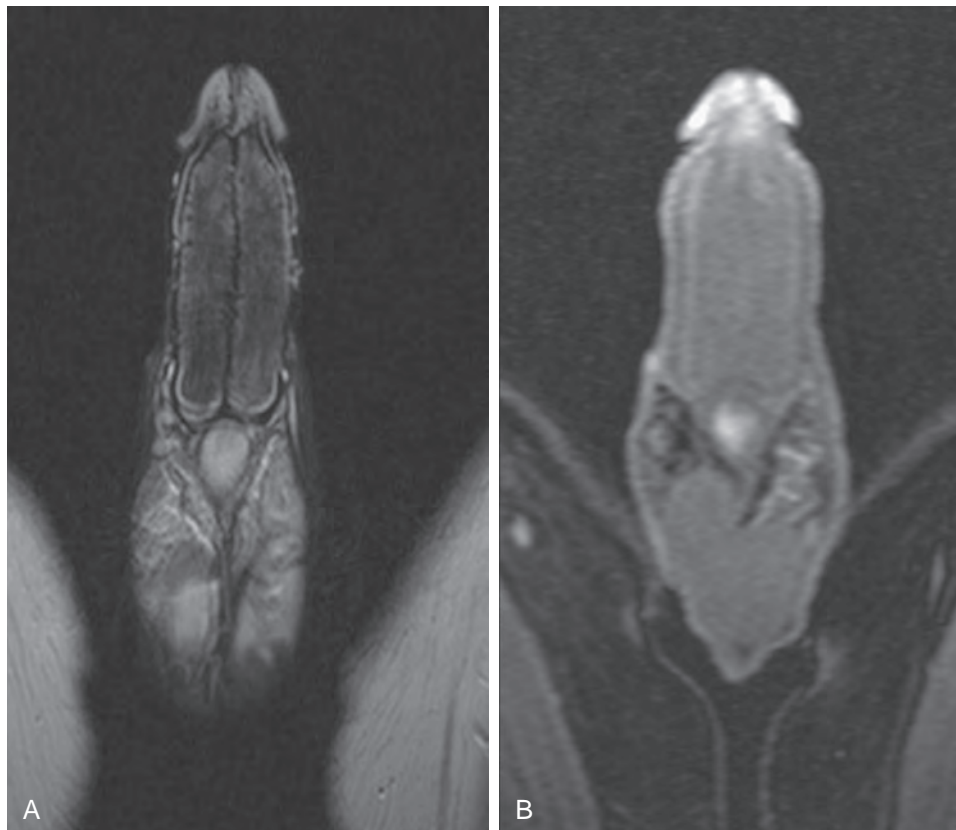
A, T2-weighted magnetic resonance image showing cavernous body thrombosis. B, Same patient. There is no enhancement after gadolinium infusion. At operation, extensive smooth muscle necrosis and thrombus were found. Patient had untreated ischemic priapism lasting several days. (Courtesy David Ralph.)
